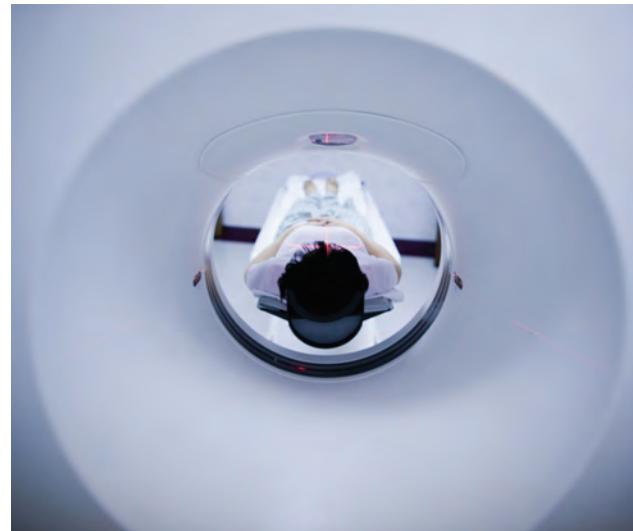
Modern technologies, such as taking a CT scan, provide detailed information about brain structure.
